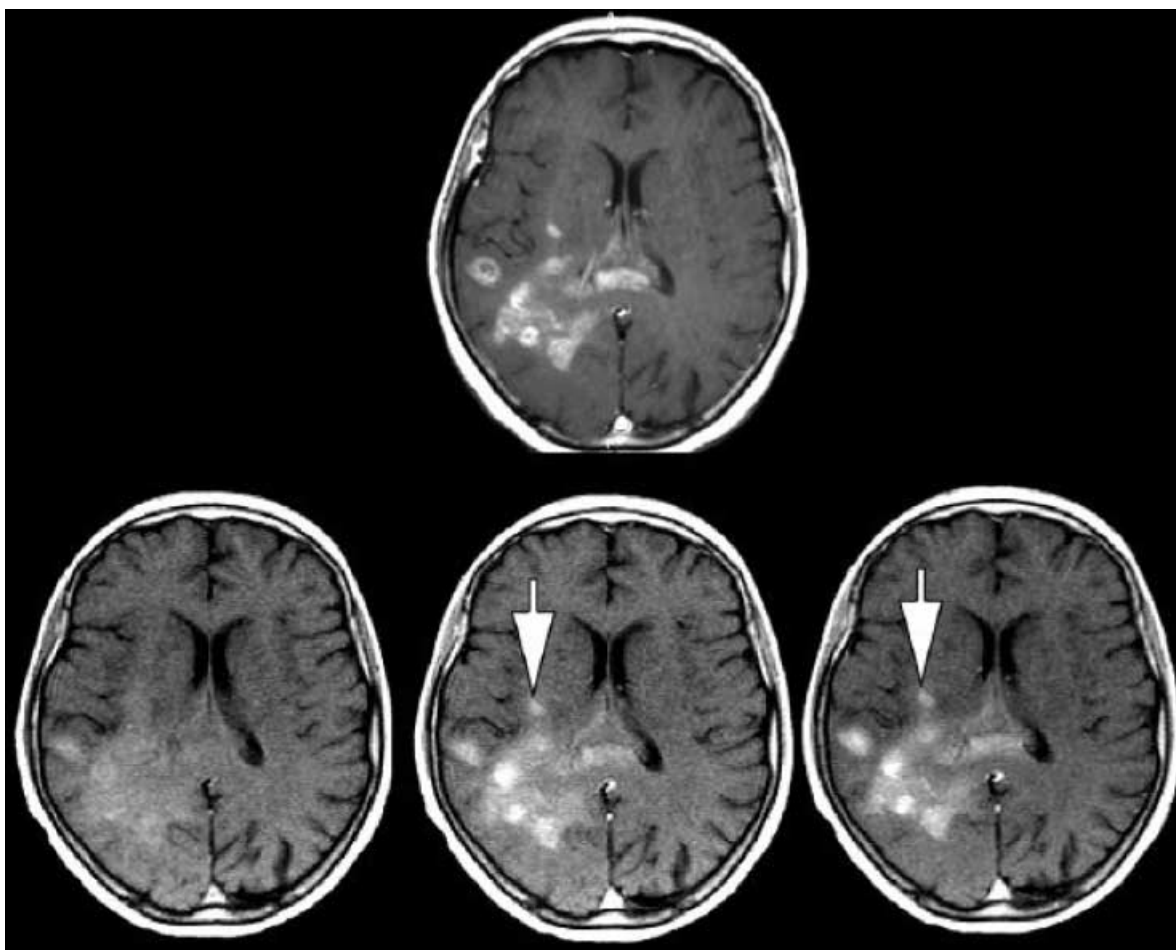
A 69-year-old woman with a right-hemispheric glioblastoma multiforme involving the splenium of the corpus callosum. *Top* A T1-weighted image obtained at 1.5 T (0.1 mmol gadolinium-DTPA/kg body weight). *Bottom* T1-weighted images obtained at 0.2 T after *left* 0.1, *middle* 0.2 and *right* 0.3 mmol gadolinium-DTPA/kg body weight. At the lower field, parts of the tumour (*arrows*) are seen to enhance only after the double or triple dose
